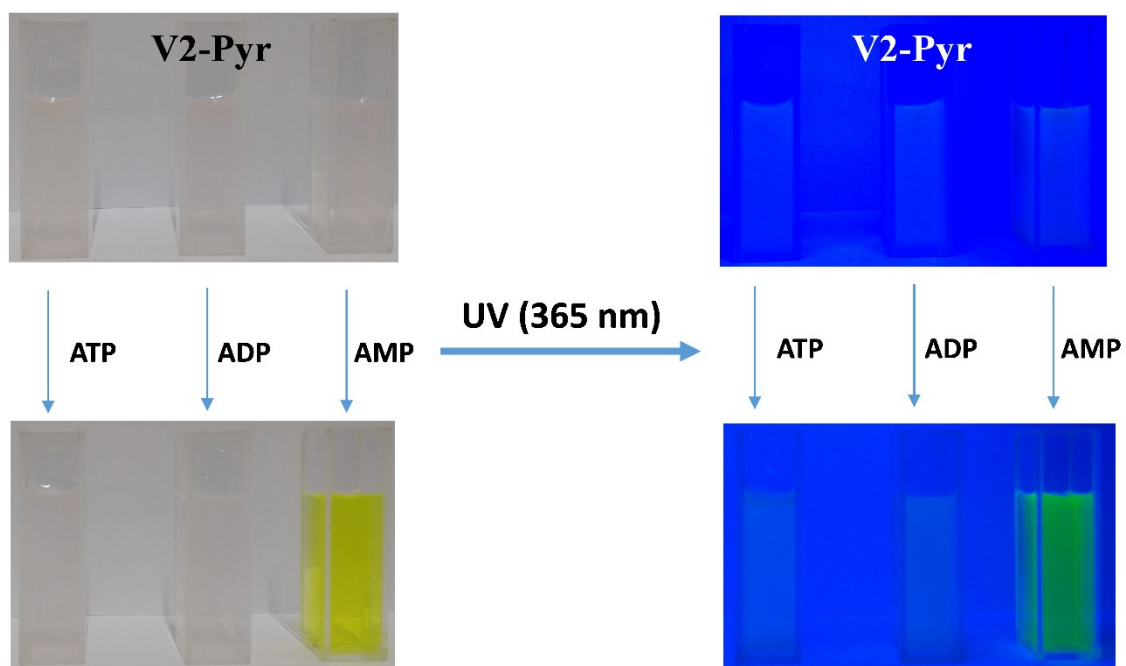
Visual appearance of disaggregation induced recognition of AMP by [V2-Pyr] CT aggregates in water.
